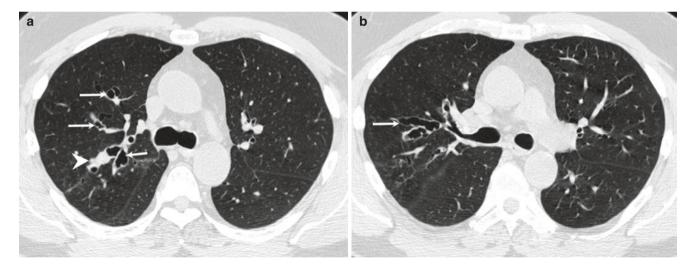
ABPA in a 50-year-old man with asthma. (a, b) CT images show focal central "varicose" bronchiectasis (white arrows) with some mucus plugging in the right upper lobe (arrowhead). Note diffuse centrilobular nodularity in both lungs that is probably due to underlying asthma
